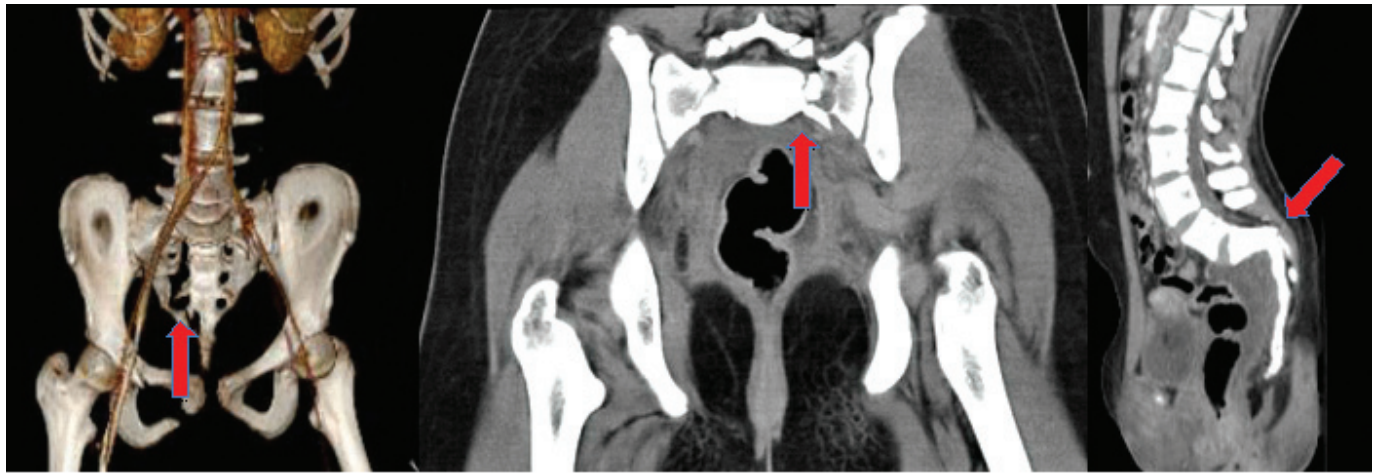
CT scan is a significant tool to assess the orientation of the sacrum specially the transverse element shown in 3D reconstruction, coronal & sagittal views (red arrows indicates the extent of sacral fractures in these views)
